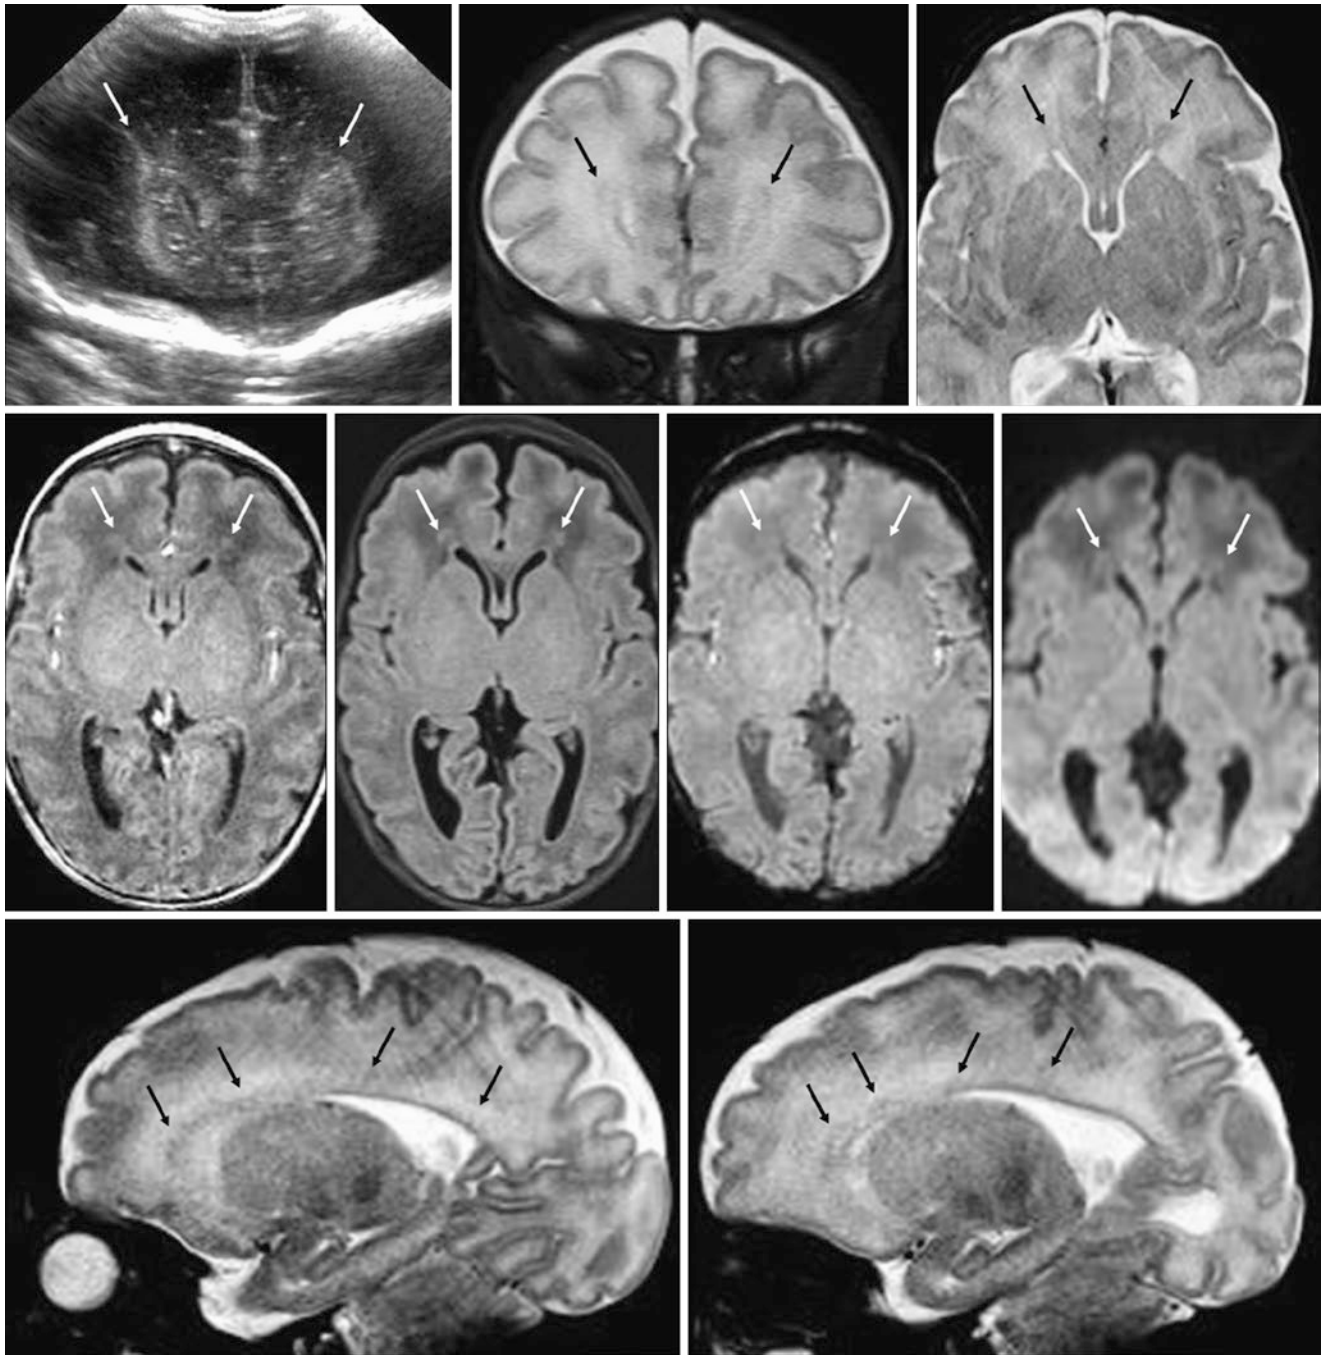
Top row:* A 36-week-old mildly premature infant had hyperechoic signal (*thin arrows*) along the frontal horns of the lateral ventricles on a coronal ultrasound (*left*); these areas were slightly dark on coronal (*middle*) and axial (*right*) SE T2WIs at 3T. This finding was presumed to represent residual germinal matrix (RGM), but motion on the axial T2WI made the RGM difficult to visualize. *Middle row:* On axial GE T1WI (*left*), the foci are shown to be in the typical location of presumed RGM, and they are nearly isointense to gray matter on
